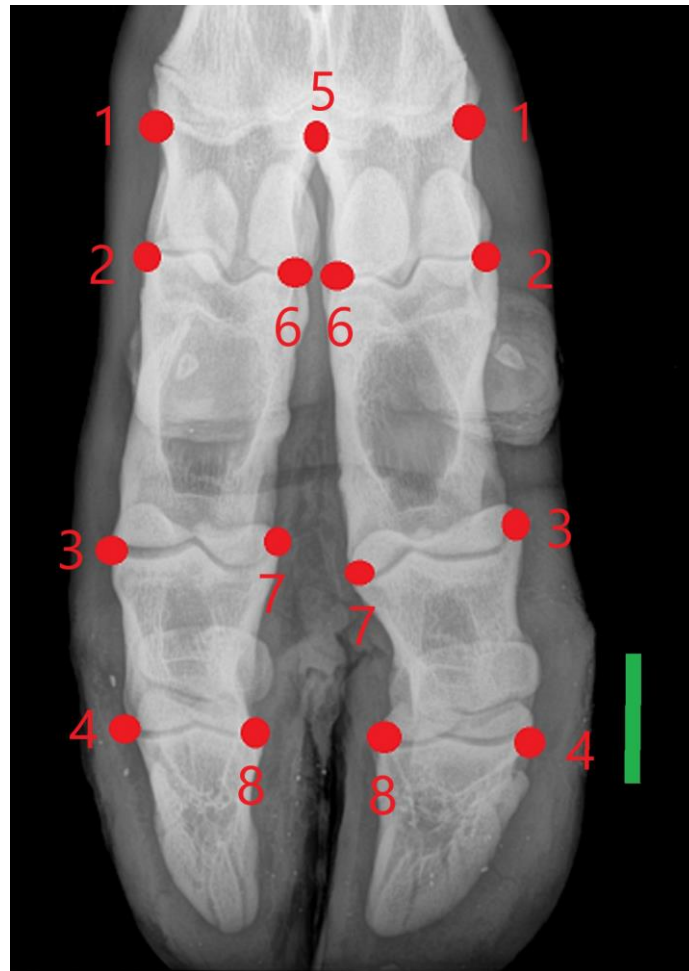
Dorso-palmar view of acropodium on which seven landmarks occurring on both sides of the acropodiums joints (2 to 4, and 6 to 8), disto-abaxial metacarpal epiphyseal bands (1) and one axial (no. 5 on the distal metacarpal epiphysis) were located. Bar is 3 cm long. For each limb the x-ray beam centered approximately to the metacarpophalangeal joint.
